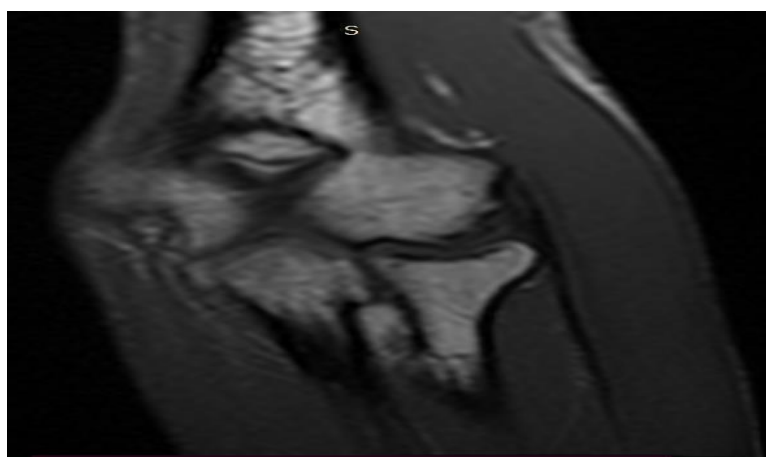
Coronal T1-weighted MR image of the right elbow showing mild fusiform enlargement of the ulnar nerve with relative effacement of the surrounding fat planes and no focal discontinuity.
